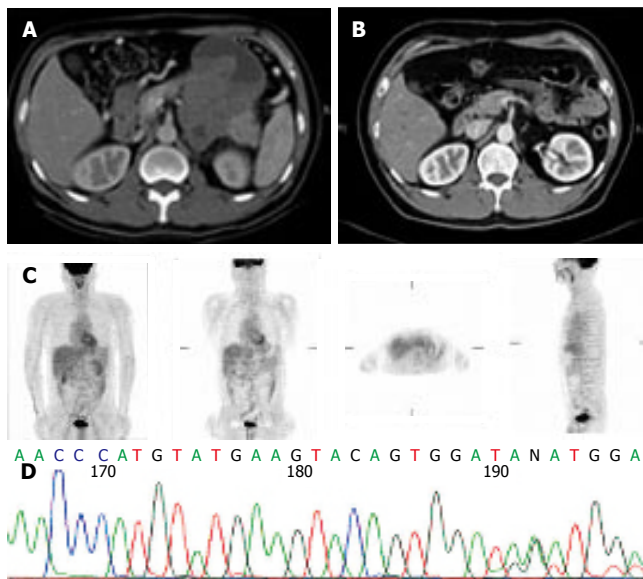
(A) Abdominal CT showing a huge retroperitoneal tumor invading the pancreas (arrow); (B) abdominal CT showing complete response without tumor at the same level as Figure 2A; (C) PET showing no tumor with metabolic activity in the whole body; (D) direct sequencing analysis of DNA from patient 2 showed deletion and insertion mutation at codons 556-557 in exon 11 (arrow).
